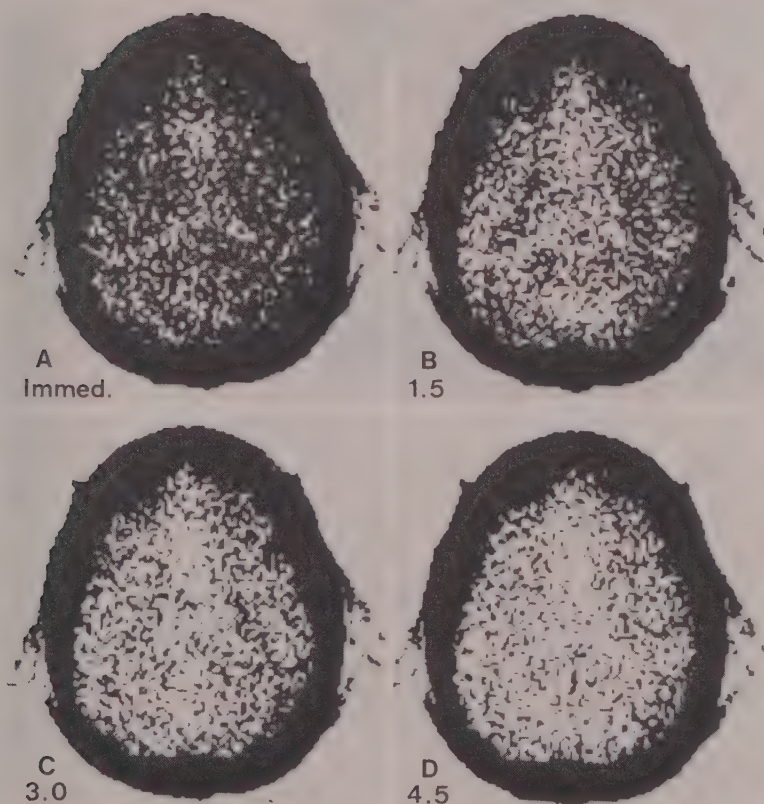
Xenon-Enhanced CT. Normal Saturation with Xenon and Normal Xenon Clearance. The images are displayed as black for white reversals at measure mode, so the calvarium appears as a black rim and each black dot represents a volume of brain with an EMI number of 27 units or greater. Case courtesy of Burton P. Drayer, University of Pittsburgh Health Center. A, CT immediately after discontinuation of xenon inhalation (70 per cent saturation) reveals the normal pattern of xenon uptake (black dots) and the central, non-enhancing lateral ventricles. B through D, Serial CT images at the same level at 1.5, 3.0 and 4.5 minutes after abrupt discontinuation of xenon inhalation demonstrates the pattern of xenon wash-out from normal brain. These serial images provide data for evaluating the kinetics of wash-out.
